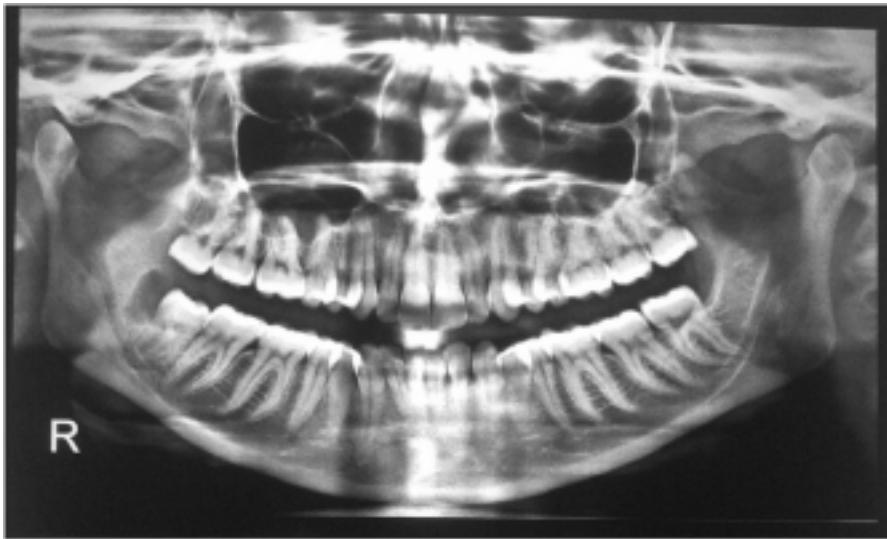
Panoramic Radiograph Shows Unilateral Radiolucency Associated With Lower Right Third Molar.
